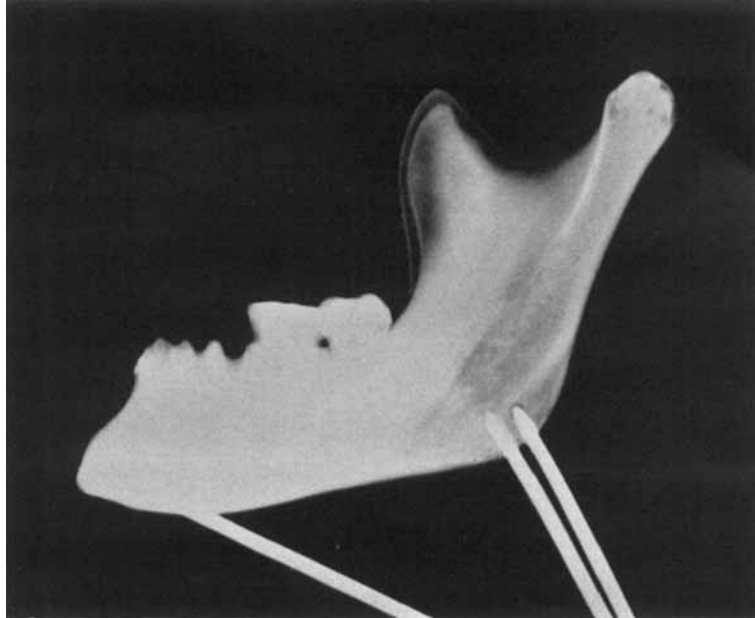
Roentgenogram of the mandible in unrotated position.
